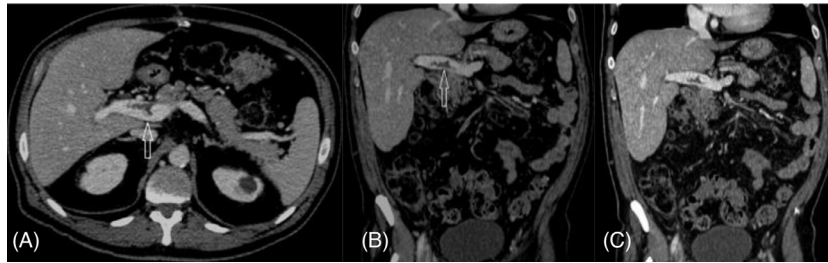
Follow-up contrast-enhanced computed tomography after 1 month. (A) Axial image showing a reduction in portal vein thrombosis (white arrow). (B and C) Coronal images showing a reduction in portal vein thrombosis (white arrow), with no evidence of superior mesenteric vein thrombosis.
